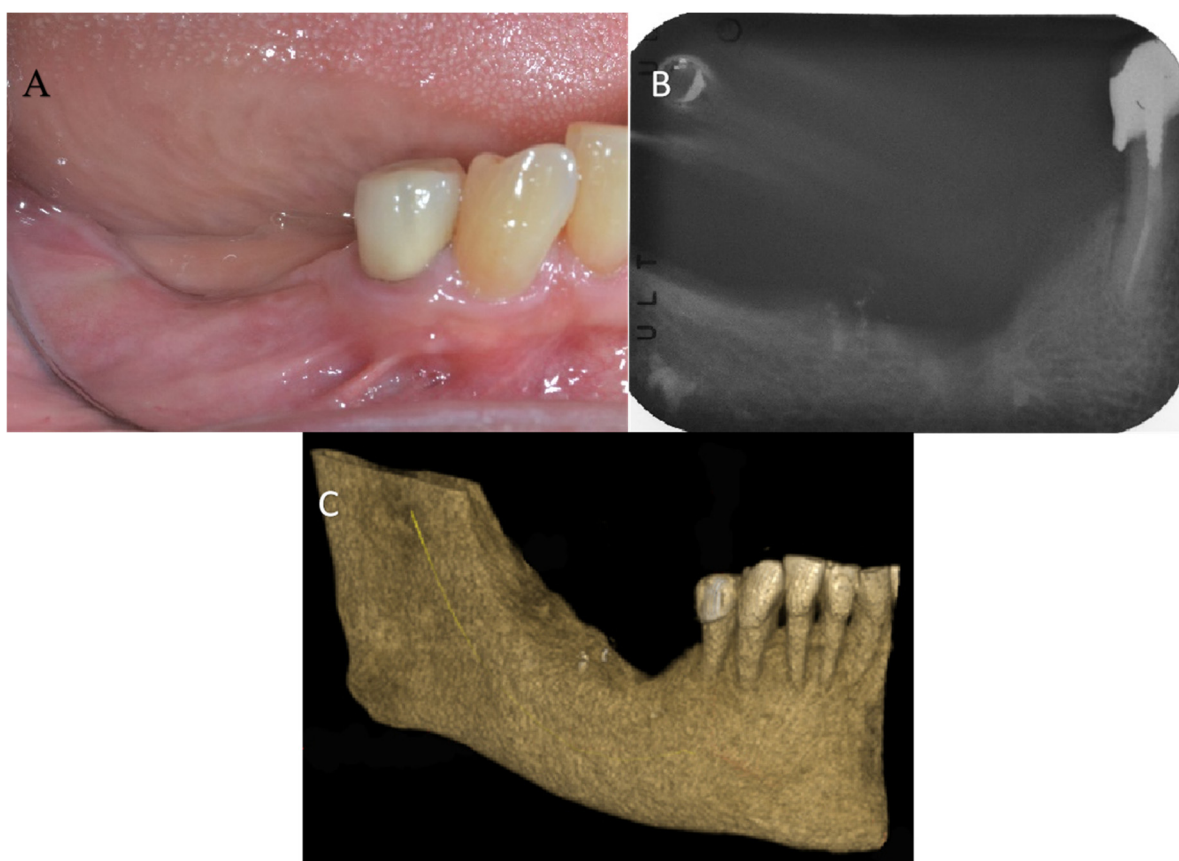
A vertical defect was evident after healing (A); Periapical radiograph (B) and cone beam computed tomography (C) revealed the amount of bone deficiency.
